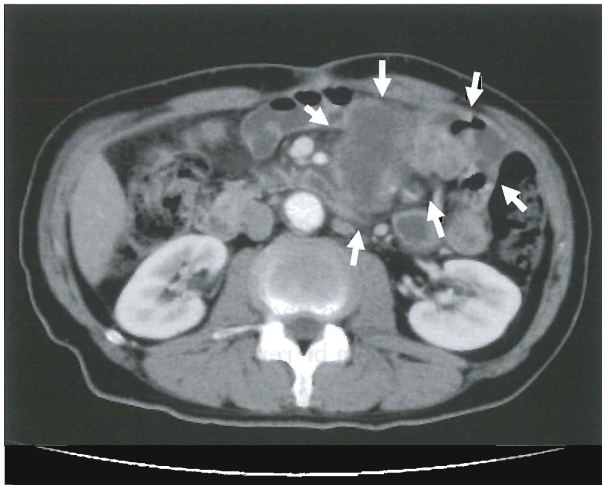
Enhanced abdominal CT on postoperative day 75, showed multiple recurrent tumor, lymph node metastasis on the mesentery and peritoneal dissemination (arrows).
